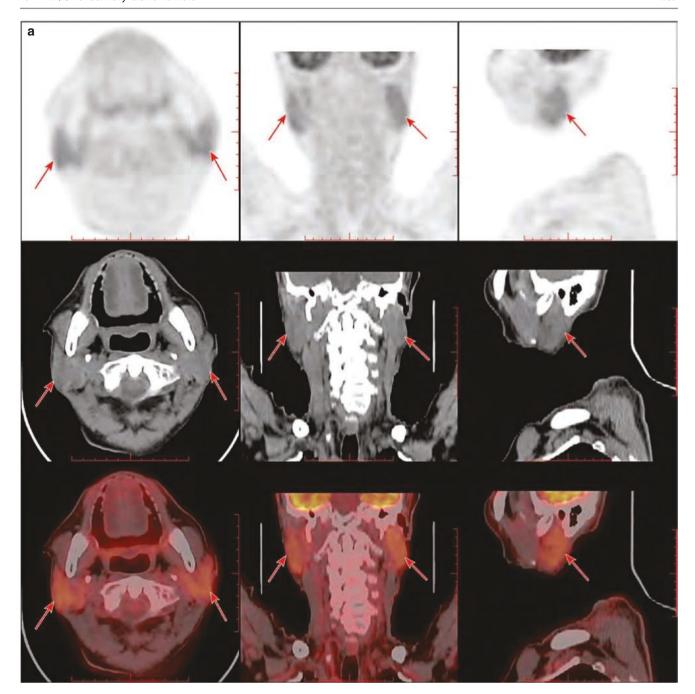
¹⁸F-FDG PET/CT images of bilateral parotid gland inflammation. A 73-year-old male patient with gastric cancer was reexamined in the hospital after operation: (a) PET/CT image of diffuse elevated metabolism of bilateral parotid glands; (b) PET/CT image of diffuse
